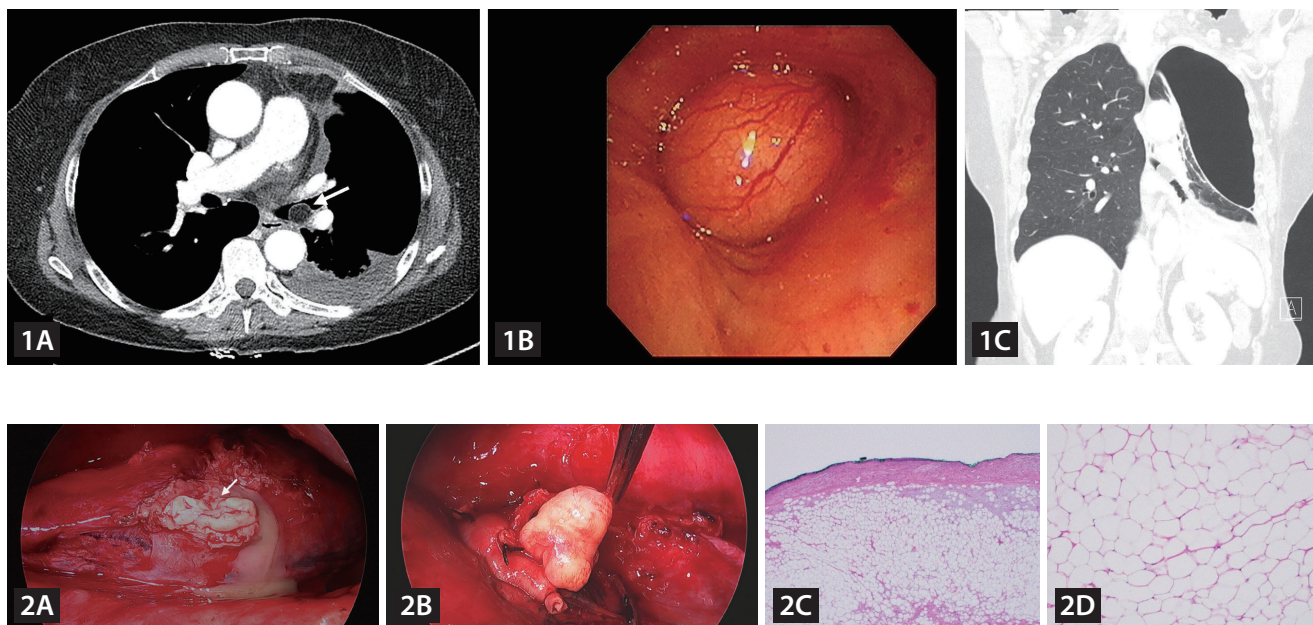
(A) Chest computed tomography (CT) revealed an endobronchial nodule with fat in the left main bronchus (arrow) and parapneumonic effusion on the left side. (B) Bronchoscopy revealed a well-circumscribed, firm, rounded endobronchial nodule in the left main bronchus. (C) Hydro-pneumothorax was evident on the left in the chest CT scan.
